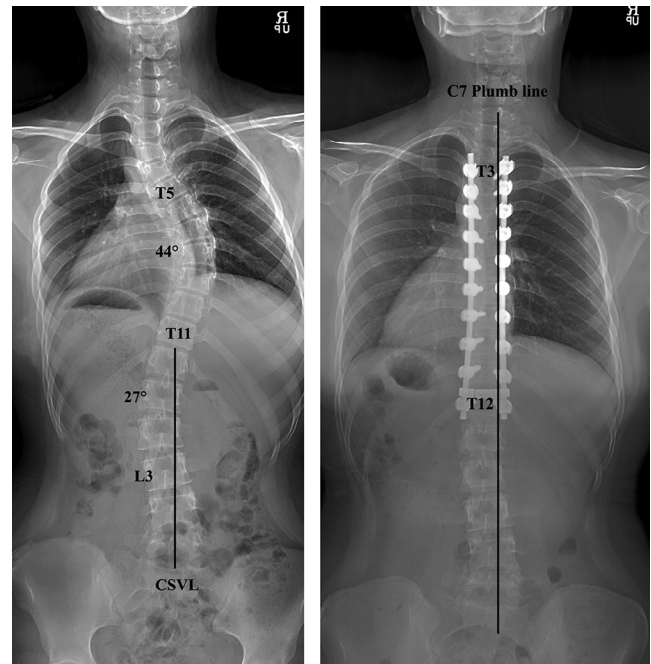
Selective thoracic fusion (STF) in a 15-year-old female patient with AIS. (Left) A whole-spine anteroposterior radiograph showed a Lenke type 1B curve. (Right) Coronal balance was well maintained following STF at 4 years postoperatively.
